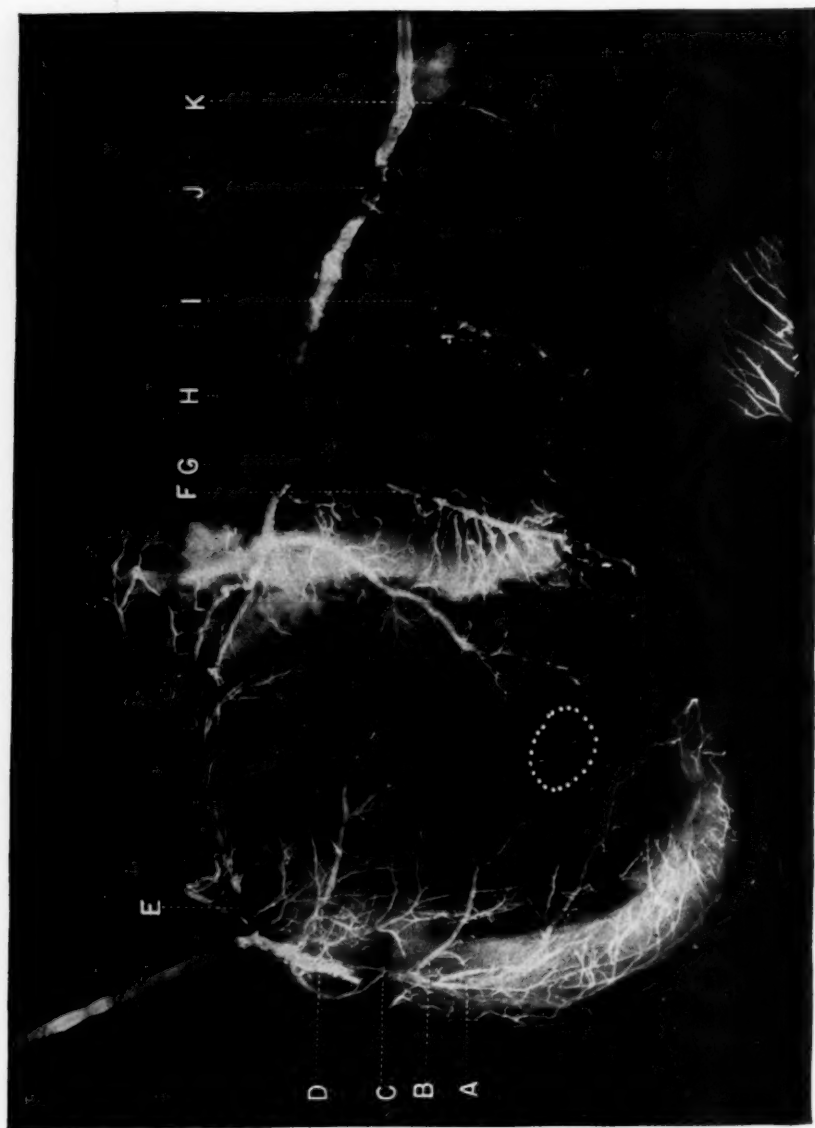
Copy of roentgenogram of injected and unrolled heart.
